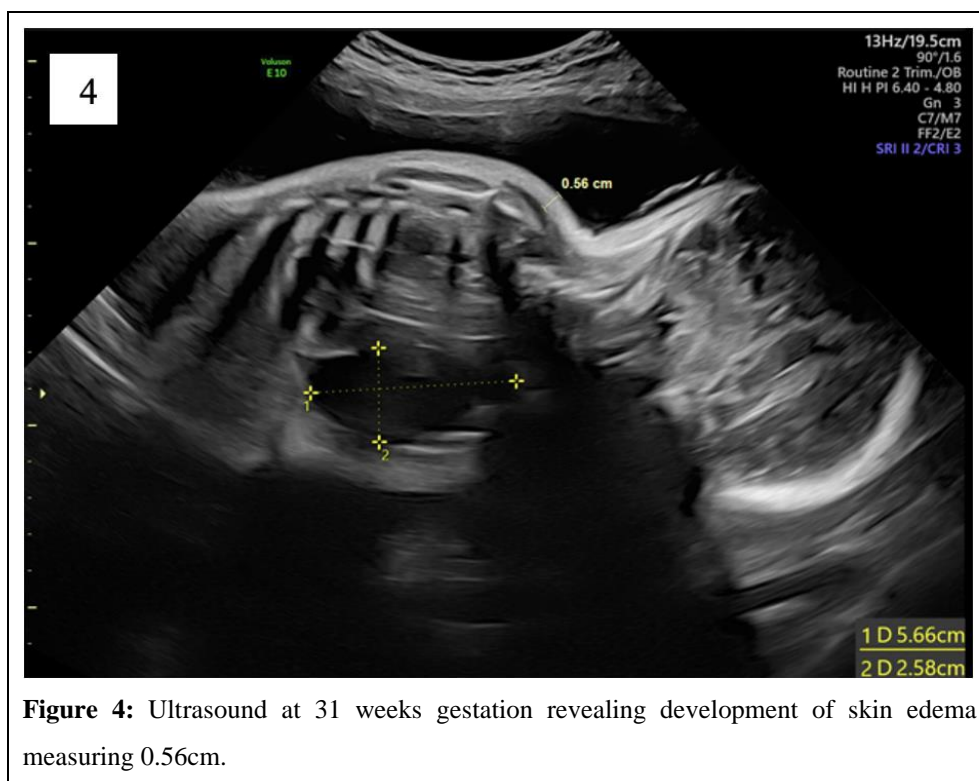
Ultrasound at 31 weeks gestation revealing development of skin edema measuring 0.56cm.
